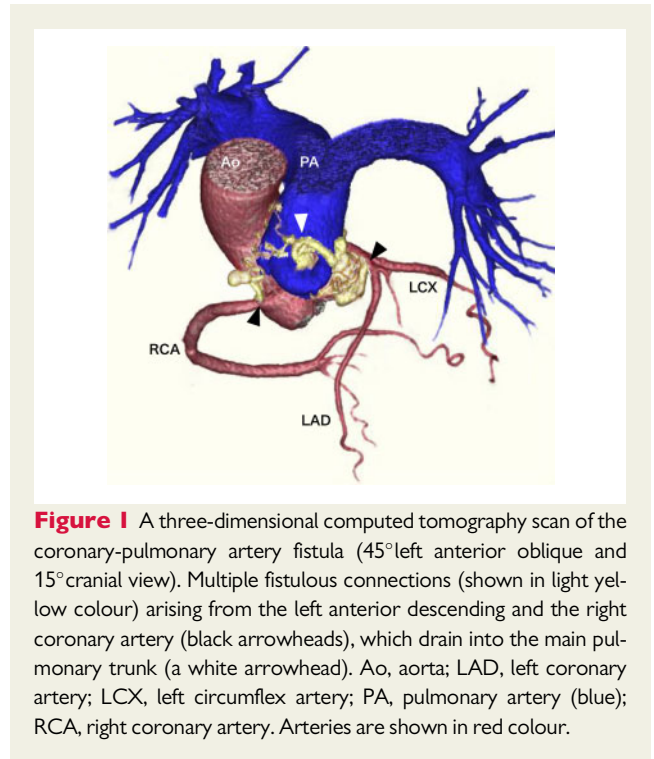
A three-dimensional computed tomography scan of the coronary-pulmonary artery fistula (45°left anterior oblique and 15°cranial view). Multiple fistulous connections (shown in light yellow colour) arising from the left anterior descending and the right coronary artery (black arrowheads), which drain into the main pulmonary trunk (a white arrowhead). Ao, aorta; LAD, left coronary artery; LCX, left circumflex artery; PA, pulmonary artery (blue); RCA, right coronary artery. Arteries are shown in red colour.
